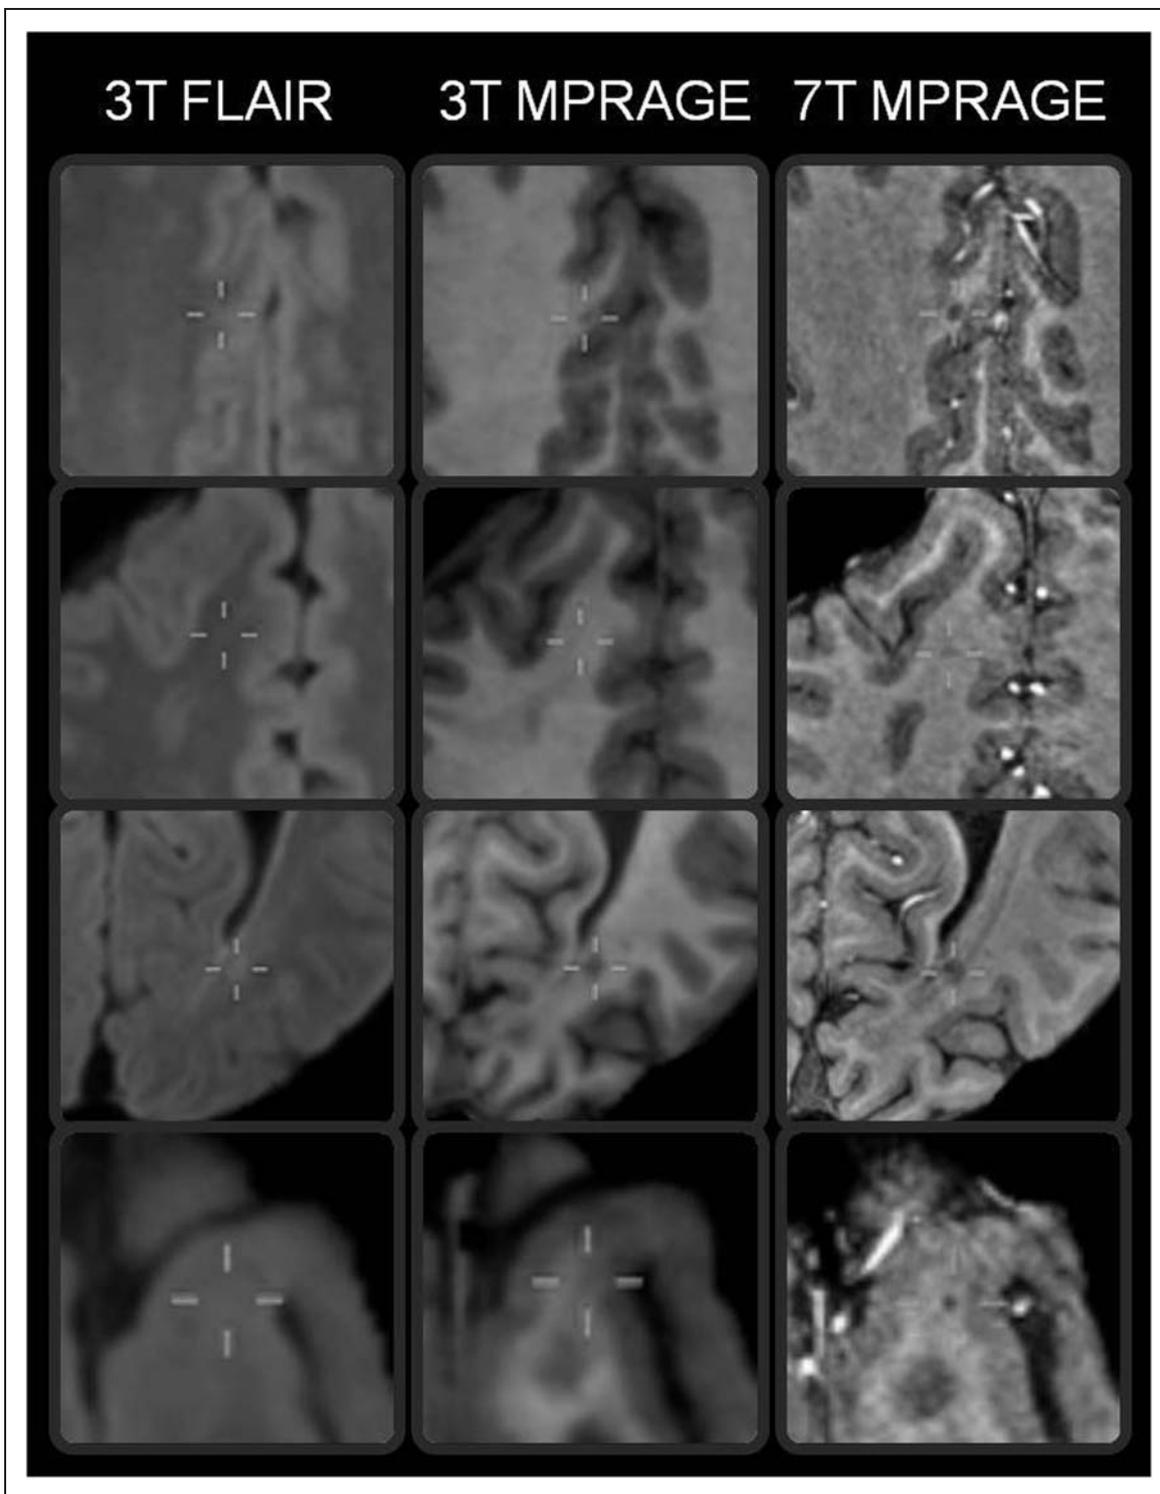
Examples of typical lesions detected by the observer using MPRAGE but not by the observer using 3T FLAIR images. The example in the third row was detected using 3T MPRAGE and 7T MPRAGE. The other examples were only detected using 7T MPRAGE. FLAIR: fluid attenuation inversion recovery, MPRAGE: magnetization prepared rapid acquisition gradient echo.
